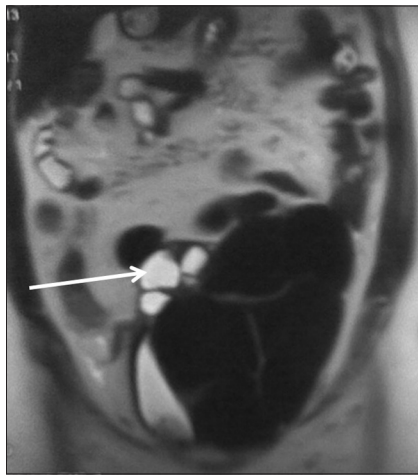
Coronal T2-weighted (T2W) magnetic resonance imaging (MRI) pelvis showing hypointense lobulated solid mass displacing the bladder laterally to the right with a cystic mass adherent to it (arrow)
